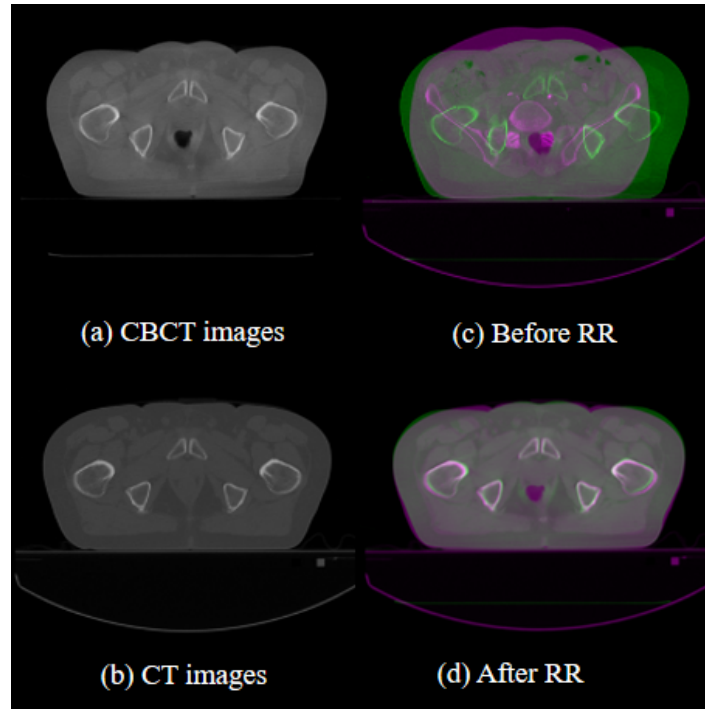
A slice of CBCT images (a), planning CT images (b) and the results of their superimposition before alignment (c) and after alignment (d) with rigid registration.
